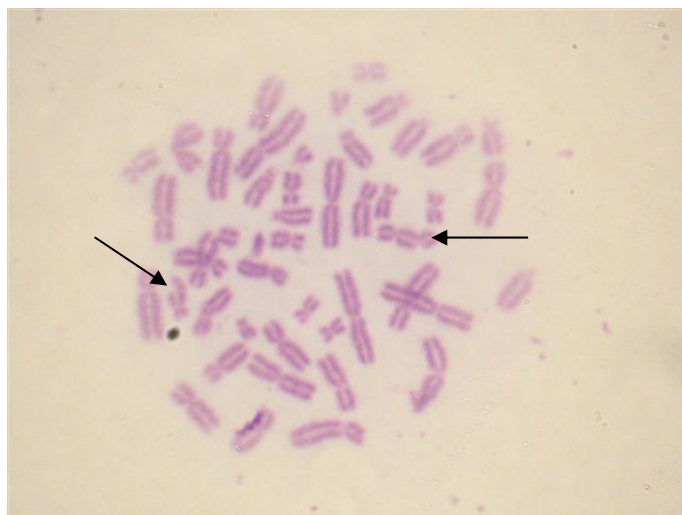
Chromatid breaks after 1 Gy of X-ray irradiation as visualized at metaphase peripheral blood lymphocyte from a healthy donor using G₂ assay. Notice two chromatid breaks.
